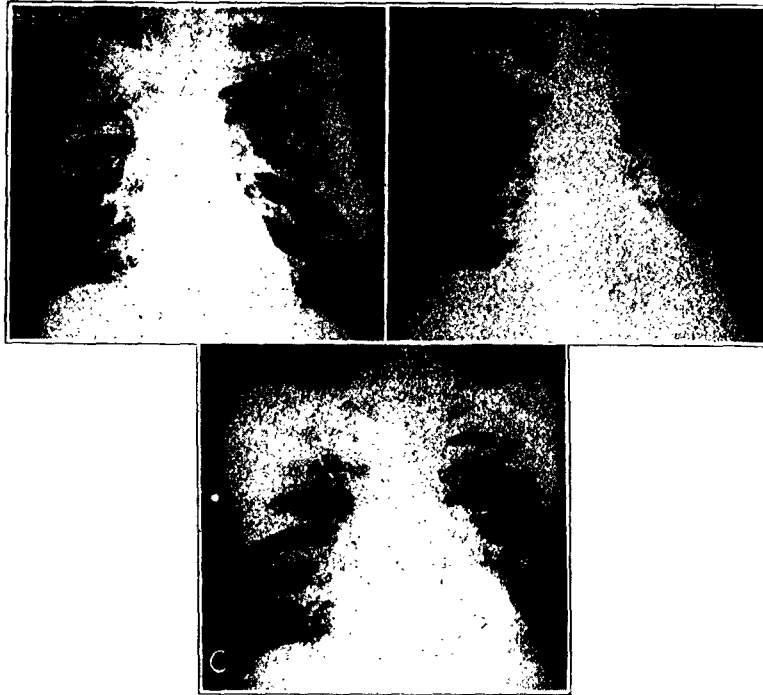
(case 1).—Serial roentgenograms taken in 1934 (A), 1943 (B) and 1947 (C) showing extensive nodulation and clearing of infection in upper lobe of right lung with resultant linear scar.
